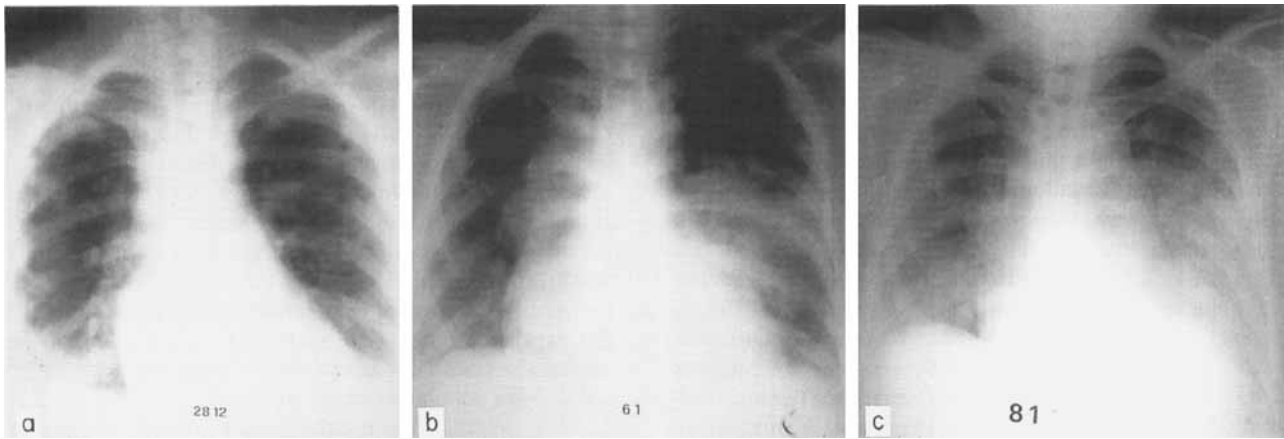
Case 3. (a) At the onset of the infection, the patient presented a right basal and a left parailar infiltrates. The patient was febrile and the neutrophil count was $<0.5 \times 10^9/l$. (b) At day 10 the clinical status with cough, pain and bronchospasm and the radiologic picture worsened. The neutrophils were $1.7 \times 10^9/l$. (c) At day 12 a further worsening of the X-ray was documented. The patient developed intense dyspnoea as well. Neutrophils were $15.5 \times 10^9/l$. The patient died the following day of haemoptysis.
